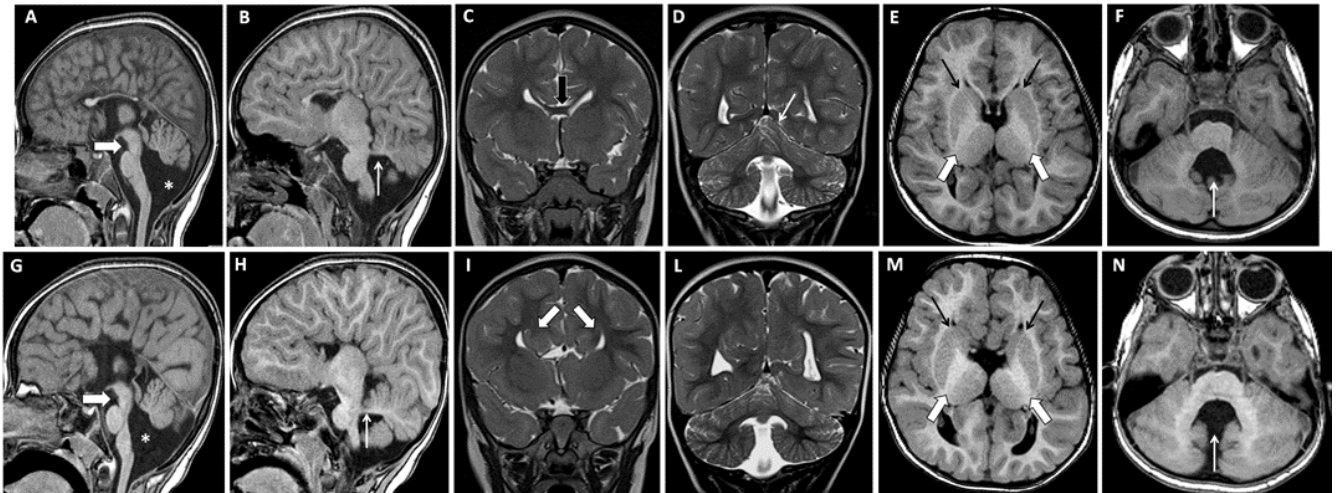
Brain MRI scans of patients II:1 (upper panels) and II:2 (bottom panels). (A-B-G-H) Sagittal T1-weighted images from volumetric GE sequence (3D MP-RAGE), showing complete commissural agenesis (corpus callosum, hippocampal and anterior commissure) in II:2 or severe commissural hypoplasia in II:1, hypoplastic and counterclockwise rotated cerebellar vermis, dysplastic brainstem with elongated isthmus (thick white arrows) and slightly hypoplastic pons, enlarged 4th ventricle widely communicating with enlarged cisterna magna (asterisks) and horizontal course with normal thickness of the superior cerebellar peduncles (thin white arrows) (C-D-I-L) Coronal T2-weighted images, displaying typical “bull’s head” appearance of the frontal horns of the lateral ventricles due to corpus callosum agenesis in II:2 (thick white arrows), hypoplastic genu of the corpus callosum in II:1 (thick black arrow) and slightly dysplastic superior vermis cortex (“rostral vermian cortical dysplasia”) (thin white arrow) (E-F-M-N) Axial T1-weighted images from volumetric GE sequence (3D MP-RAGE), exhibiting enlarged “umbrella-shaped” 4th ventricle (thin white arrows), dysplastic internal capsule with hypoplastic anterior limb (thin black arrows) and “hyperplastic” posterior limb (thick white arrows) (“tubulin-like” appearance).
